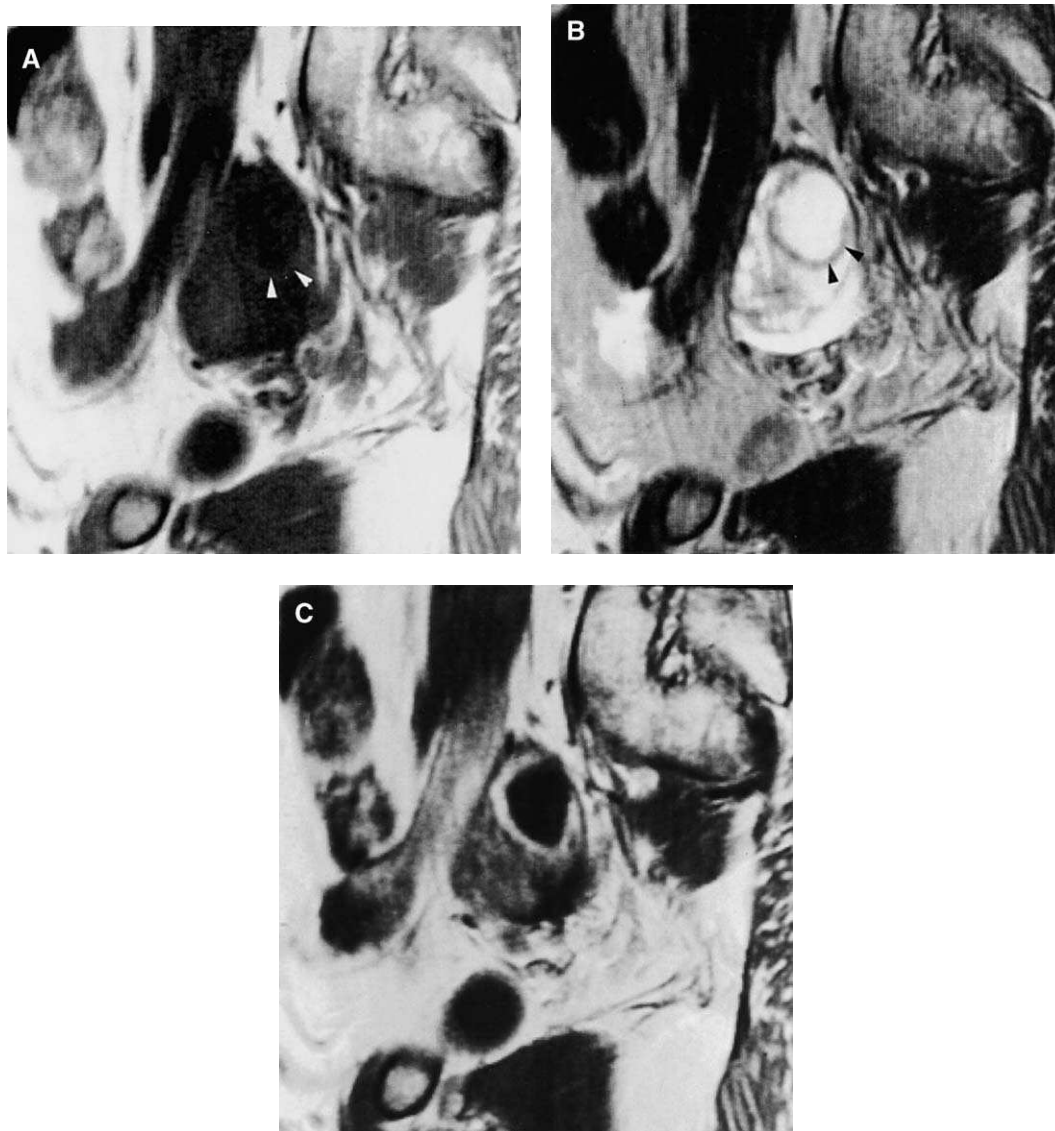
Normal ovary with a corpus luteum; a cyst distinctly larger than others. (A) T1-weighted image shows thin line of high intensity that represents a hemosiderin deposit along the wall (*arrowheads*). (B) T2-weighted image shows a line of relatively low intensity along the wall (*arrowheads*). (C) Postcontrast image shows a thick, enhancing, and convoluted wall.
